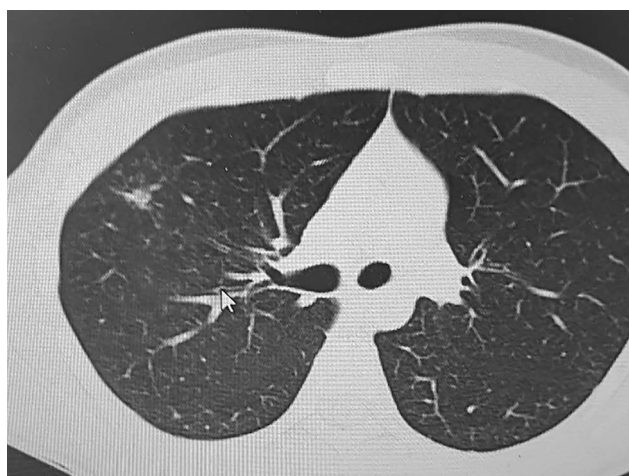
Control CT in the 2nd month of treatment – a small residual fibrotic focus is observed in the right upper lung at the cavity site.
